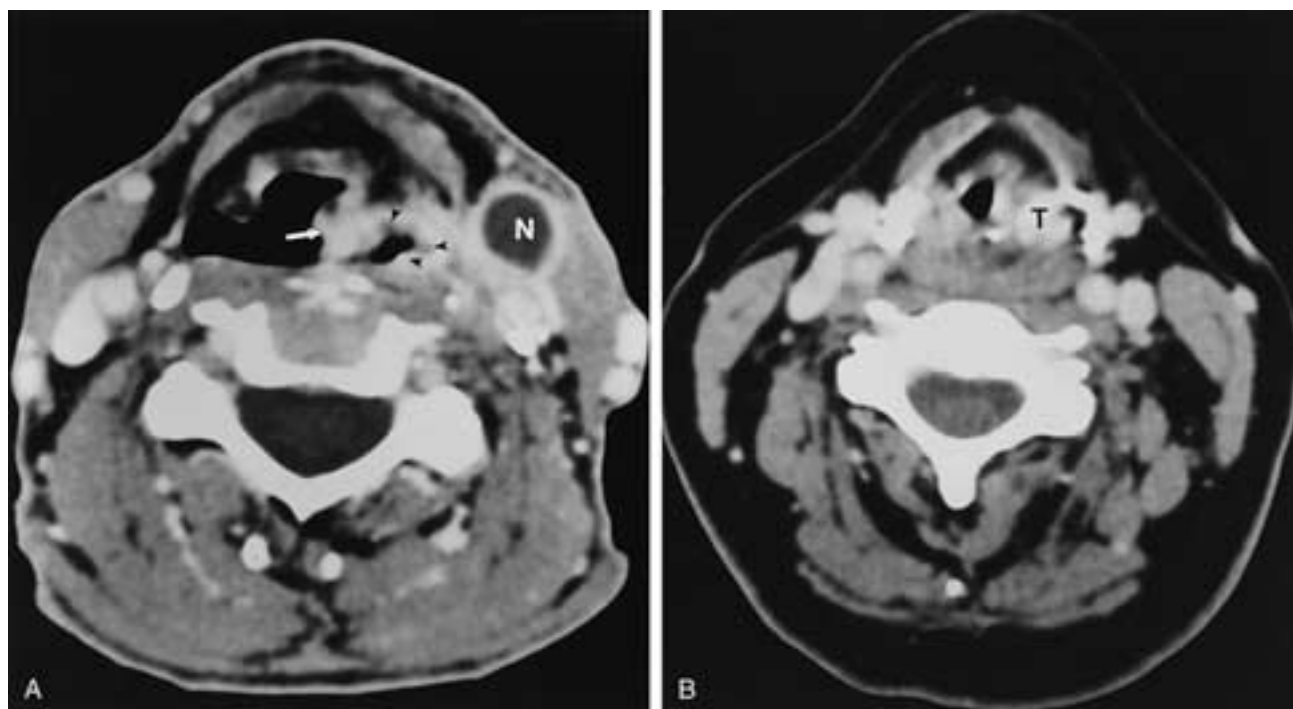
CT of a pharyngeal tumor limited to the level of the supraglottic larynx. A, The lesion (arrowheads) extends around the lateral wall of the pharynx onto the posterior wall. The AE fold (arrow) is involved. Typical appearance of a metastatic node (*N*). B, Lower margin of the tumor (*T*) is seen on the axial scan at the level of the supraglottic fat. The scan immediately inferior to this was normal.
